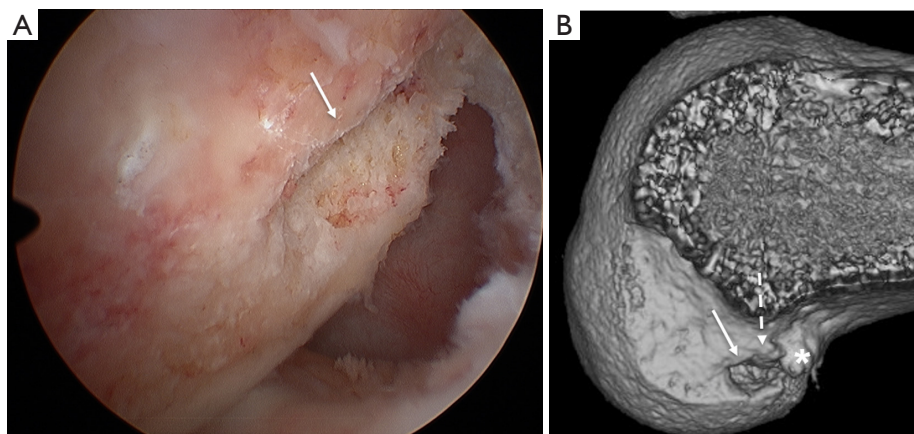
A rectangular femoral tunnel created inside the attachment areas for a BTB graft (solid arrow). (A) Arthroscopic view through AM portal; (B) aperture on 3D CT image. *, note the bone plug (dotted arrow) fixed with the interference screw. BTB, bone-patellar tendon bone; AM, anteromedial.
